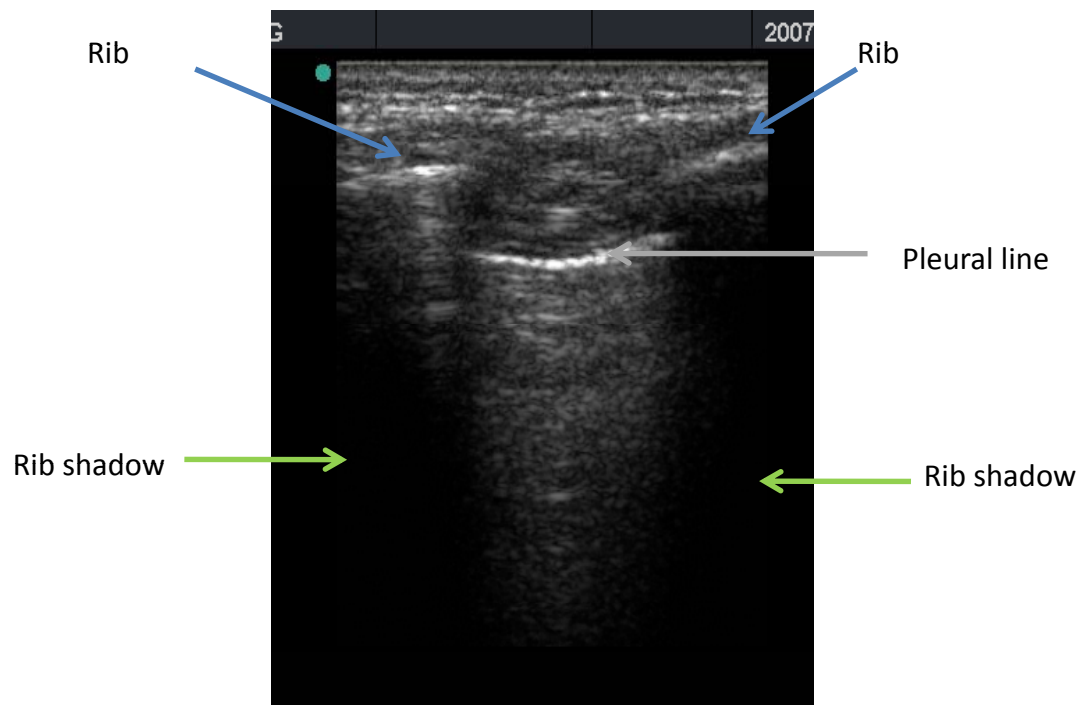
Ultrasound showing ribs on either side of the pleural line. The ribs cast acoustic shadows. The pleural line is about 0.5cm below the ribs.
